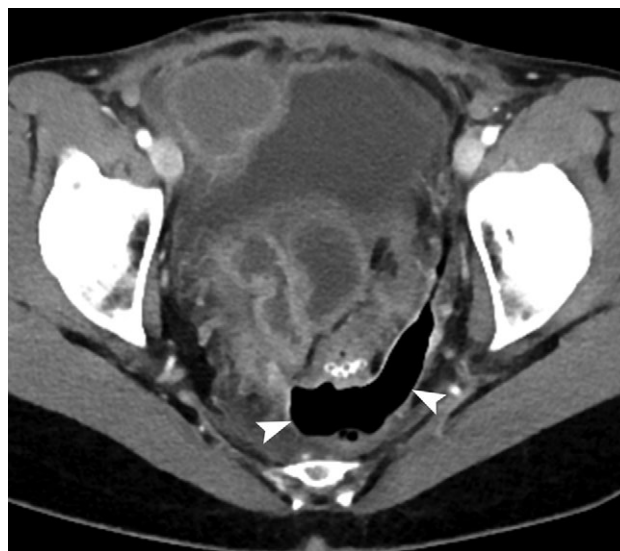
CT scan of pelvis from postoperative Day 13. Extraluminal gas in the presacral space suggested a persistent anastomotic leak (arrowheads).
